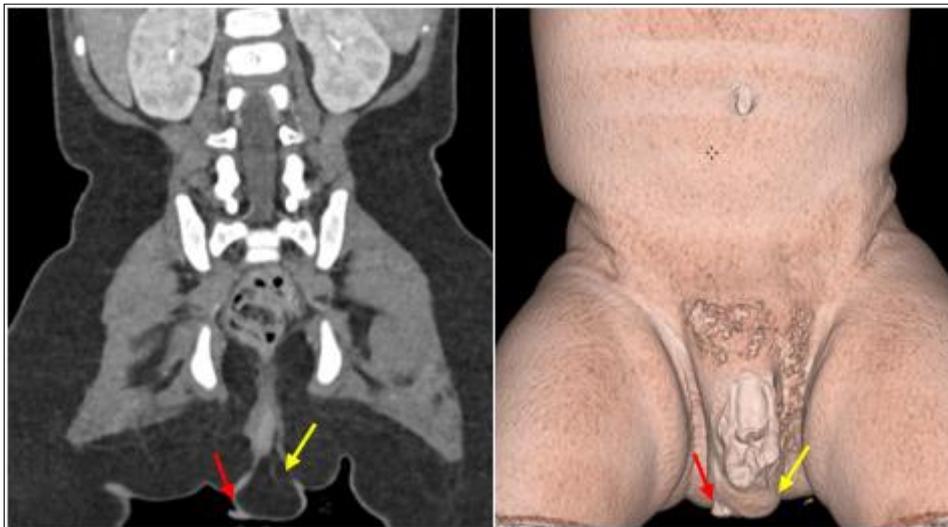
Pelvic CT scan after intravenous contrast injection in coronal sections (a) and 3D reconstructions (b) showing a perineal lipoma (yellow arrow) associated with an accessory scrotum (red arrow)
